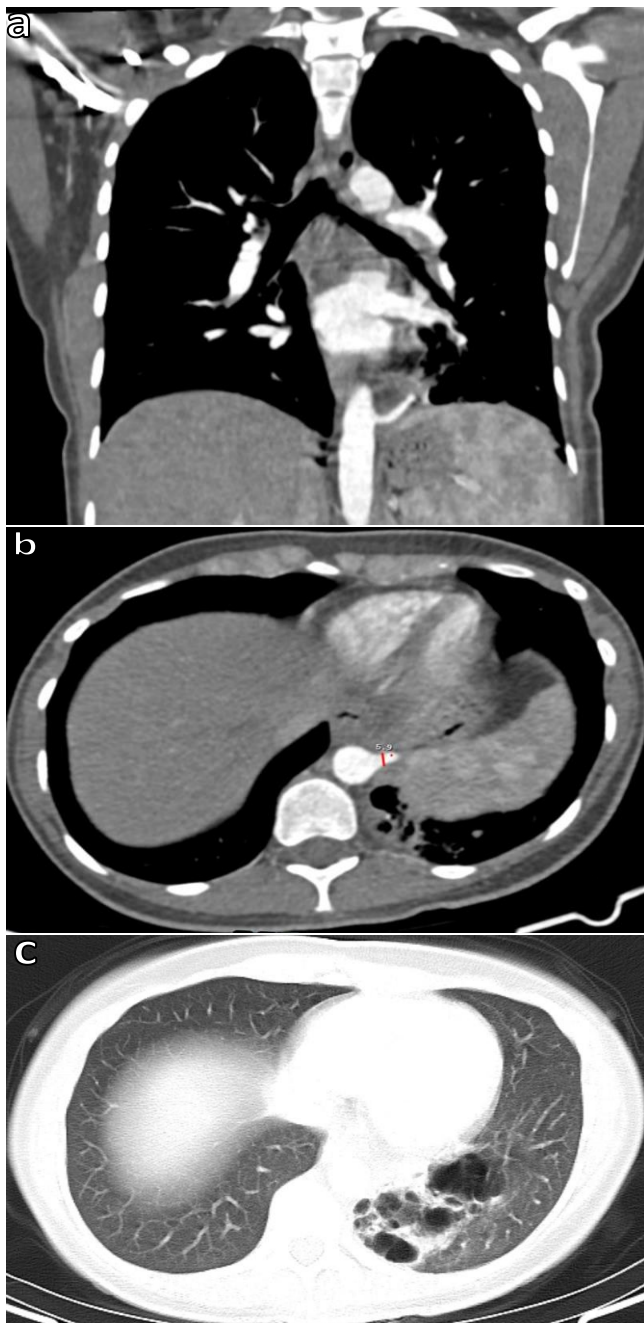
Coronal and axial view of the feeding artery on a thoracic CT image (a, b and c) diffuse and prominent segmental cystic bronchiectasis on a thoracic CT image
